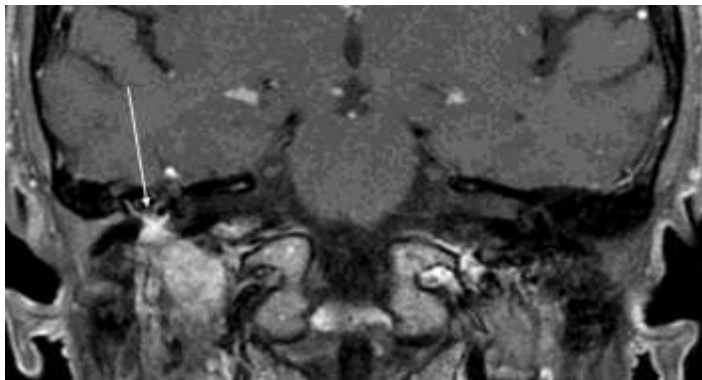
Paraganglioma; coronal MPR from a 3D contrast-enhanced T1-weighted turbo filed echo with fat saturation sequence revealing a lively enhancing lesion in the infralabyrinthine region of the right inner ear (arrow).
